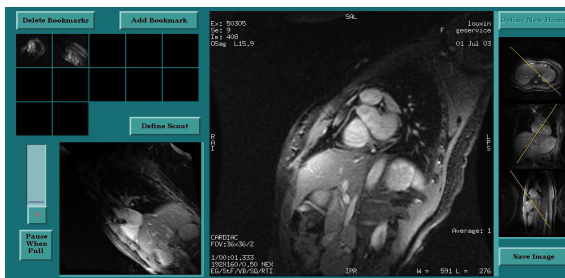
A RCA image shown from the interactive MRI interface.
